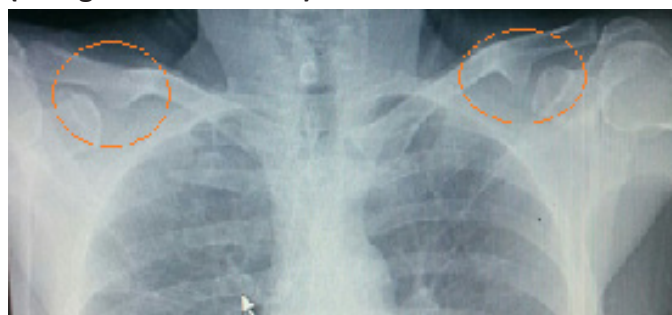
Radiograph of thoracic region (PA view) of 45 year old male showing bilateral presence of CCJ (orange encircled area).
